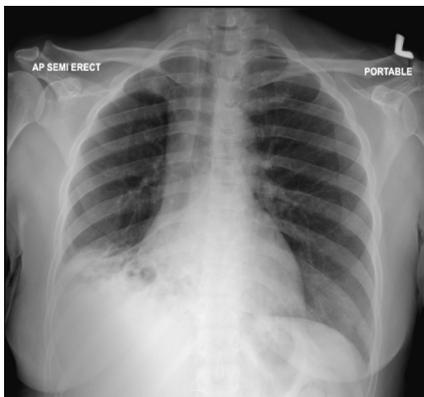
Chest radiograph AP view shows ill-defined air-space opacities with multiple cystic lesions at the right lower zone (arrow) causing partial obliteration and elevation of right hemidiaphragm; likely collapse consolidation and suspicious bronchiectasis.
